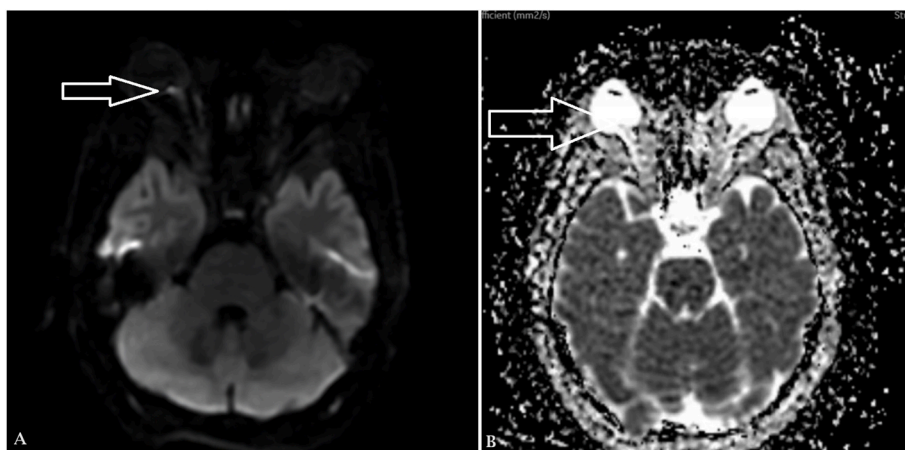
(A, B): Diffusion restriction of the optic nerve head is indicated by A) MRI DWI axial scan demonstrating focal diffusion restriction in the right optic nerve head. B) ADC demonstrating hypo-intensity near the right optic nerve head.
